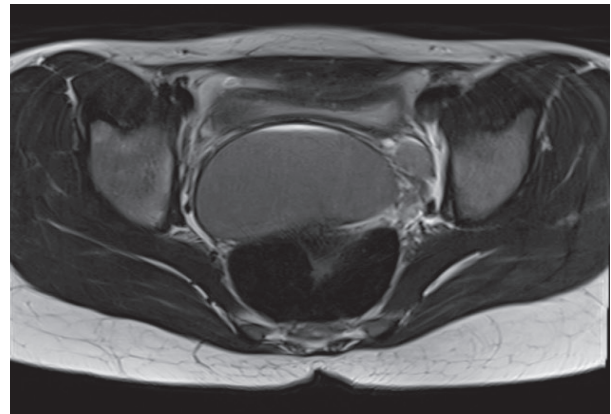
T2 Weighted MRI, Axial View
